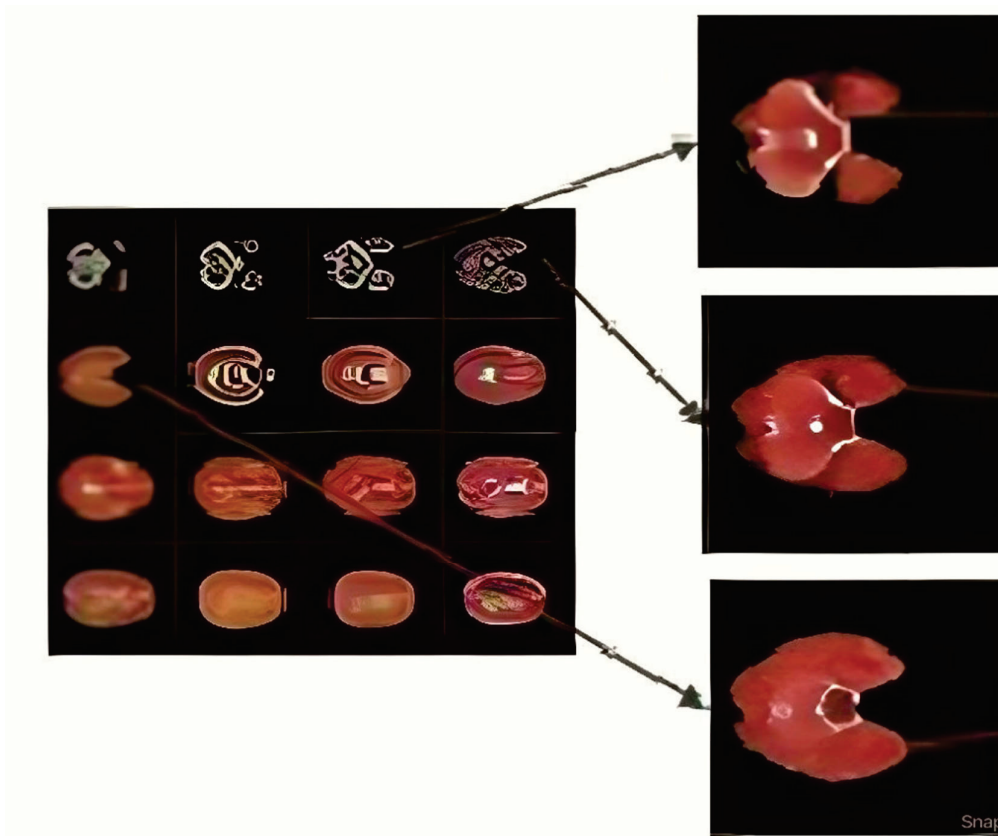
MRI compression using core wavelet families.
